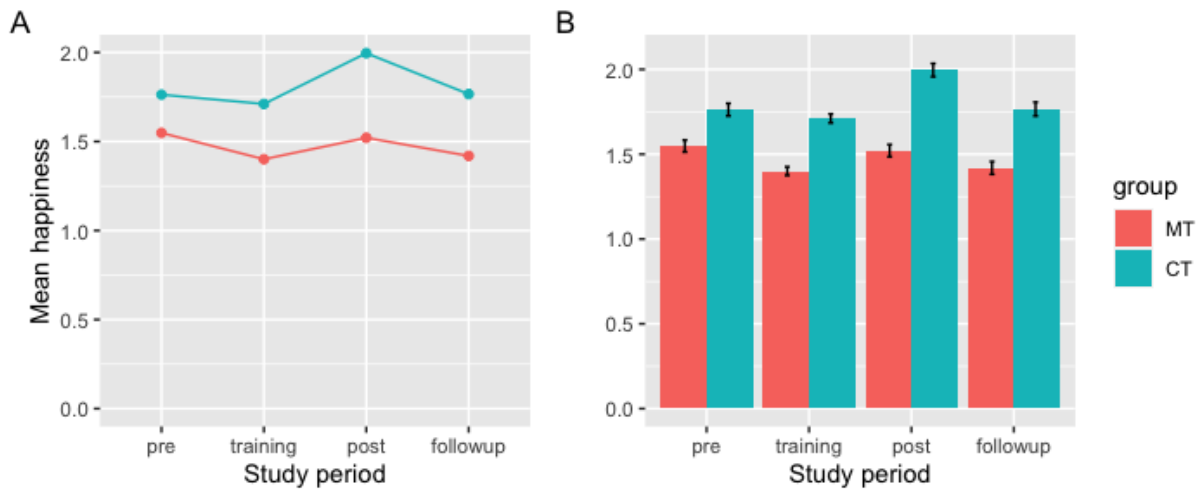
Average happiness scores across the study; MT = mindfulness training; CT = control training
